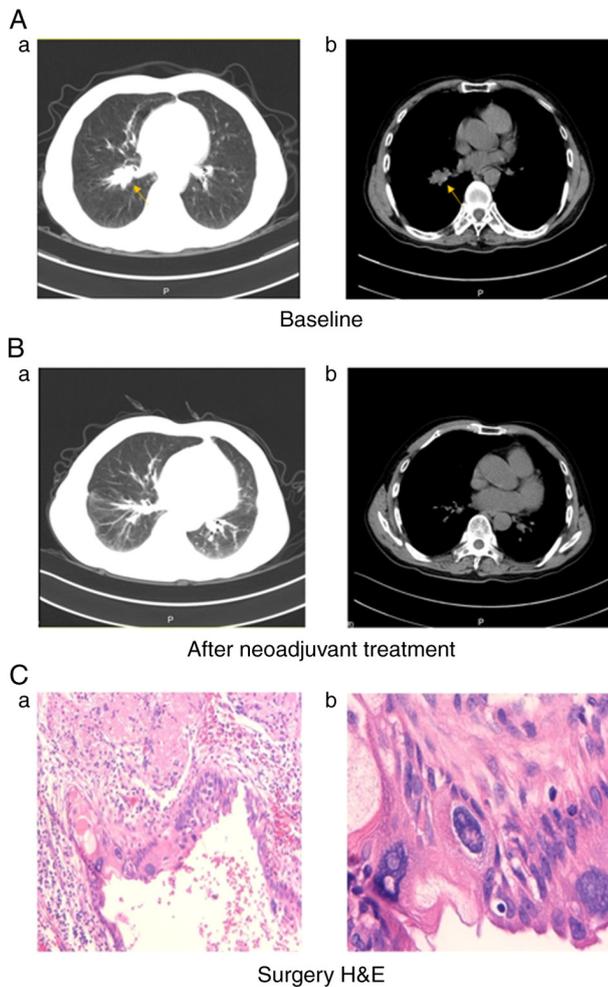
Chronological summary of imaging examination and pathological images of patient 1, a 63-year-old male, who underwent surgical resection. (A) At the baseline (March 2019), the CT scan showed a 3.1x2.3 cm right lung nodule (arrow). (a) Chest CT in a lung window; (b) chest CT in mediastinal window (B) Two months later, after two cycles of neoadjuvant chemotherapy consisting of nab-paclitaxel+nedaplatin and Endostar (May 2019), the CT scan showed no nodules. (a) Chest CT in a lung window; (b) Chest CT in mediastinal window. (C) The pathological diagnosis was severe dysplasia of the squamous epithelium derived from residual tumors identified at lamina propria of bronchial margin (magnification, x100 in a and x400 in b).
